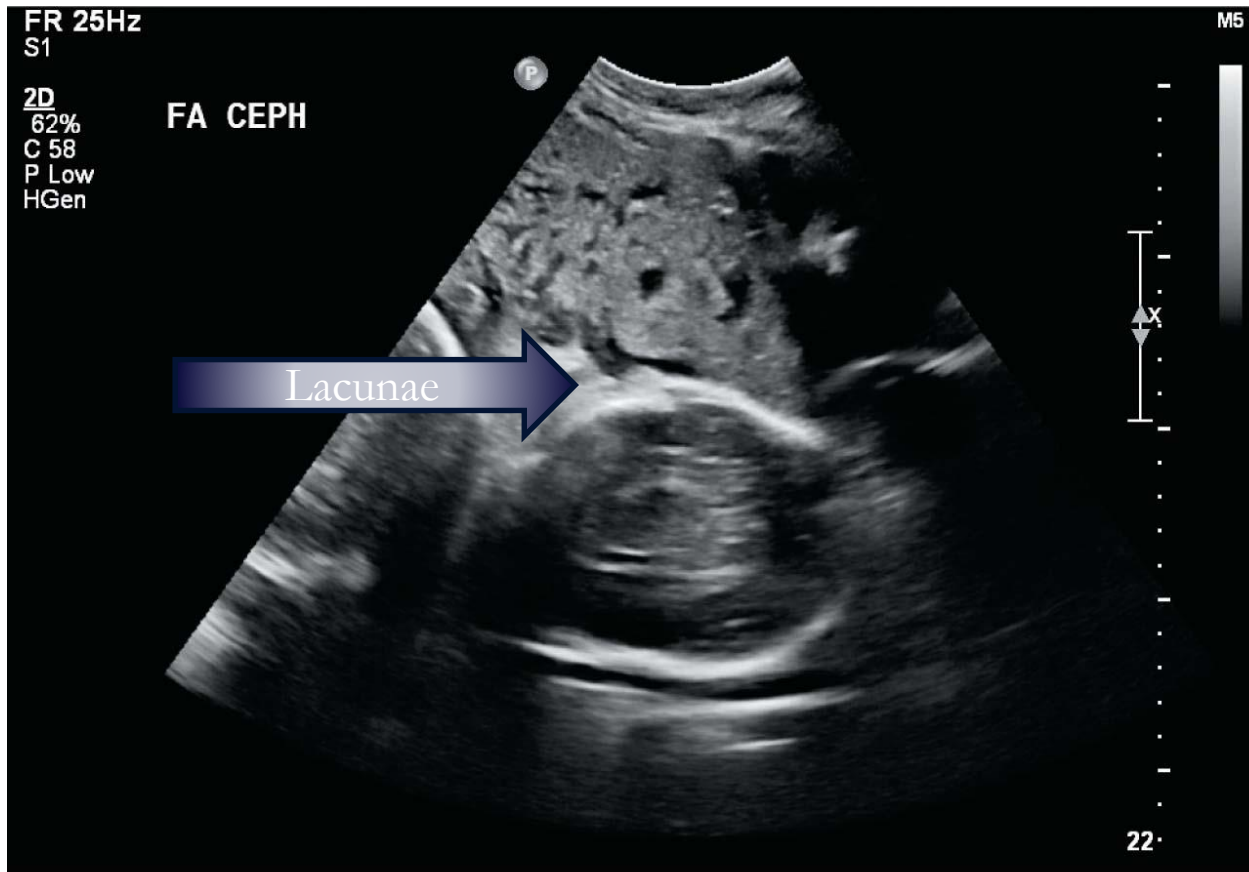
Ultrasound is an excellent screening test for accreta, with a sensitivity of 77%–93% and a specificity of 71%–91%.
